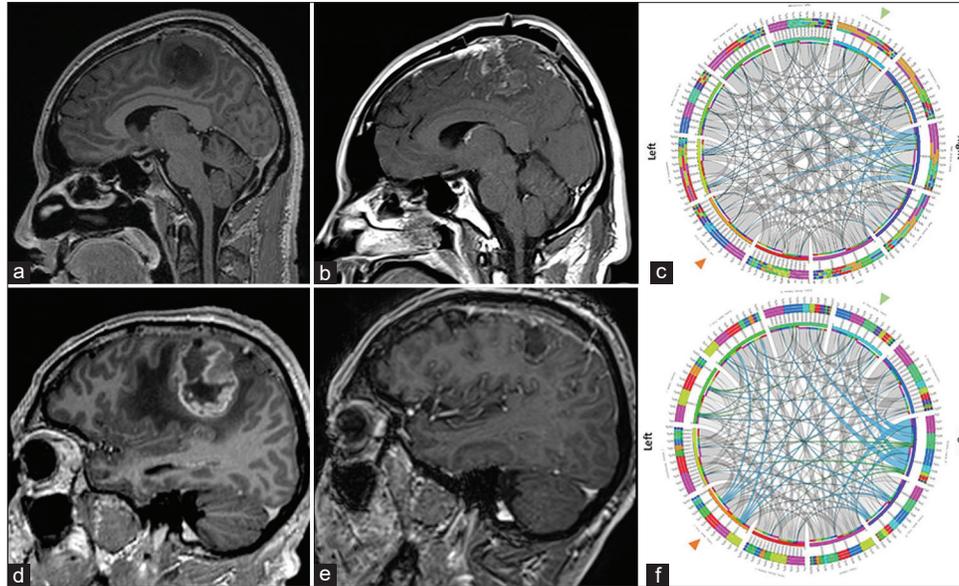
Neuroimaging of an oligodendroglioma Grade 2 and of an isocitrate dehydrogenase (IDH) IDH_{mut} astrocytoma, Grade 4. Case 1. Oligodendroglioma Grade 2. (a) Preoperative axial T1 postcontrast imaging demonstrating a nonenhancing perirolandic hypointense tumor. (b) Immediate postoperative enhanced magnetic resonance imaging (MRI) demonstrating near total resection of the tumor. (c) Preoperative connectivity map. White fibers are arranged in a symmetric distribution in both, left and right cortical tracts, noting in blue an increased signal diffusion in the right Aslant tract. Green arrowhead: Right corticospinal tract, Orange Arrowhead: Left corticospinal tract. Case 2. IDHmut astrocytoma, grade 4. (d) Preoperative enhanced MRI demonstrates a large enhancing perirolandic tumor consistent with a high-grade glioma. (e) 3-month follow-up MRI demonstrates adequate control with no enhancing tumor. (f) Preoperative connectivity map. White fibers are arranged in a symmetric distribution in both, the left and right cortical tracts, note in blue an increased signal diffusion in the right Aslant tract, the left corticospinal tract, and the right external capsule. Green arrowhead: Right corticospinal tract, Orange Arrowhead: Left corticospinal tract.
